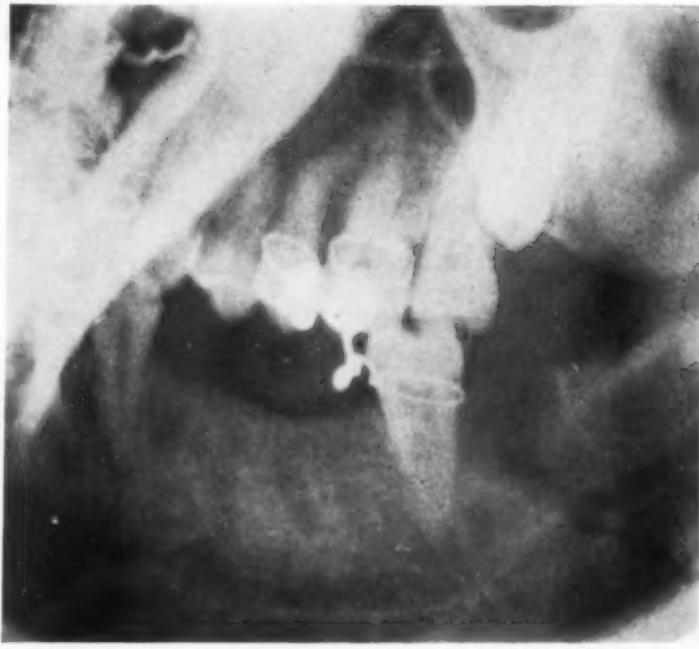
X-ray film of left jaw, showing unerupted third molar removed without disturbance of alignment of fragments, and intermaxillary ligation applied.
